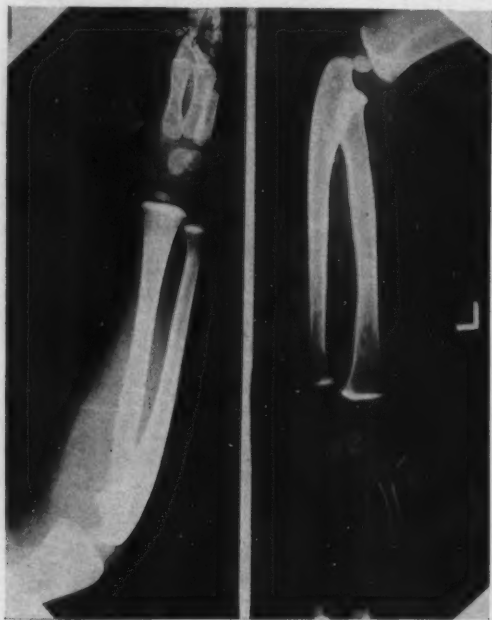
J. B.: X-ray of the left upper extremity following the traumatic incident. There is no evidence of fracture or periosteal pathology, but the bands of radio density of the distal ends of the radius and ulna are quite evident.
